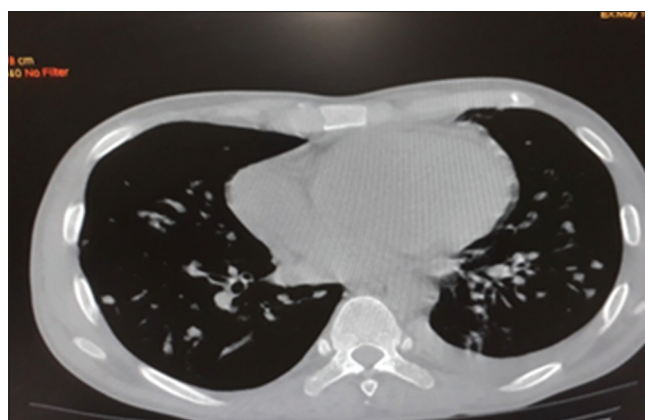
Computed tomography thorax image showing pleural effusion on left side with multiple nodules in both lung
